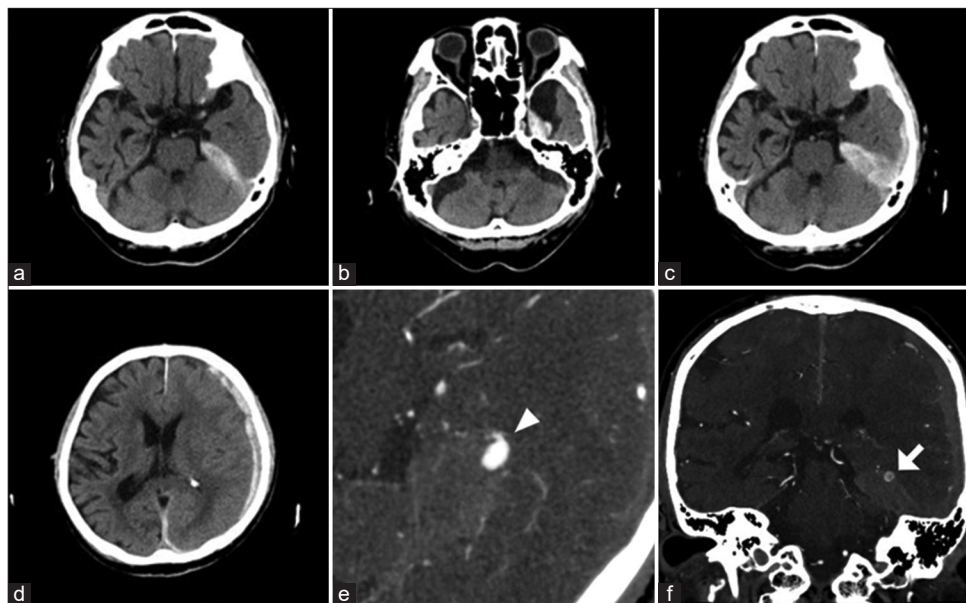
(a and b) Initial computed tomography (CT) scan showing left tentorial acute subdural hemorrhage (ASDH). (c and d) A CT scan during the second admission showed enlarged ASDH. (e and f) CT angiography showing left pseudoaneurysm in the P3 segment of the posterior cerebral artery (arrowhead) (arrow).
